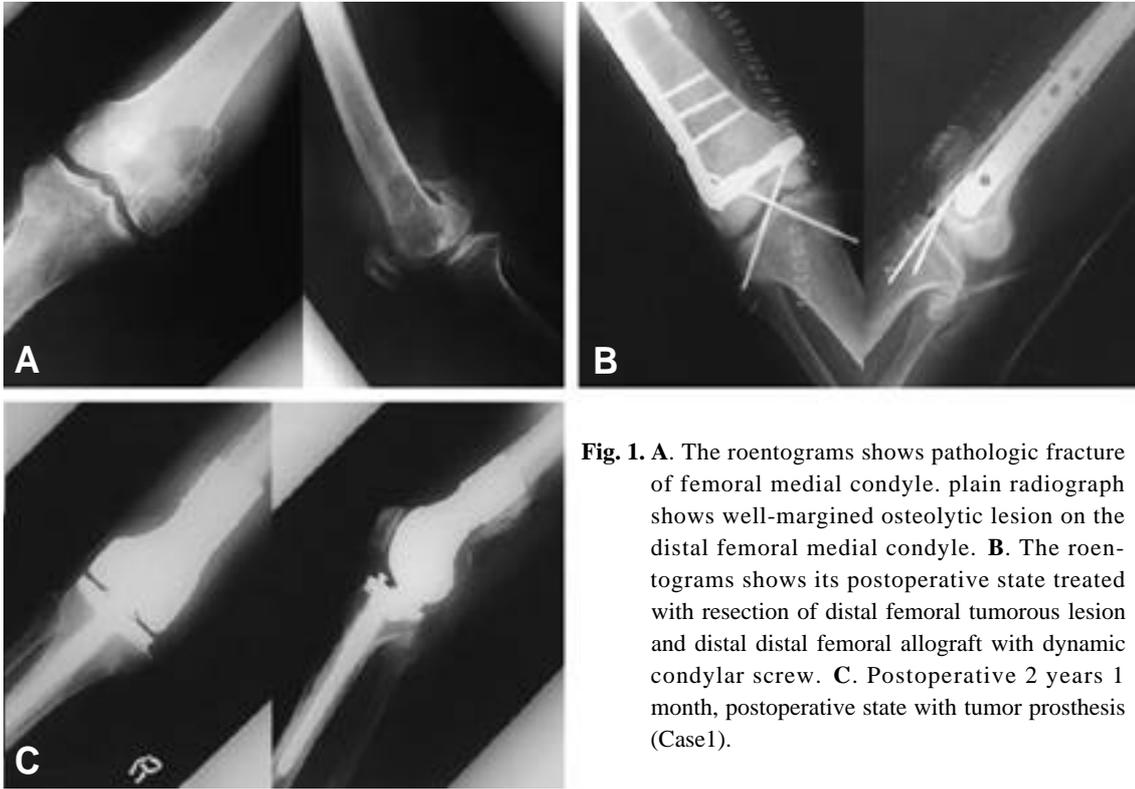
A. The roentograms shows pathologic fracture of femoral medial condyle. plain radiograph shows well-margined osteolytic lesion on the distal femoral medial condyle. B. The roentograms shows its postoperative state treated with resection of distal femoral tumorous lesion and distal distal femoral allograft with dynamic condylar screw. C. Postoperative 2 years 1 month, postoperative state with tumor prosthesis (Case1).
